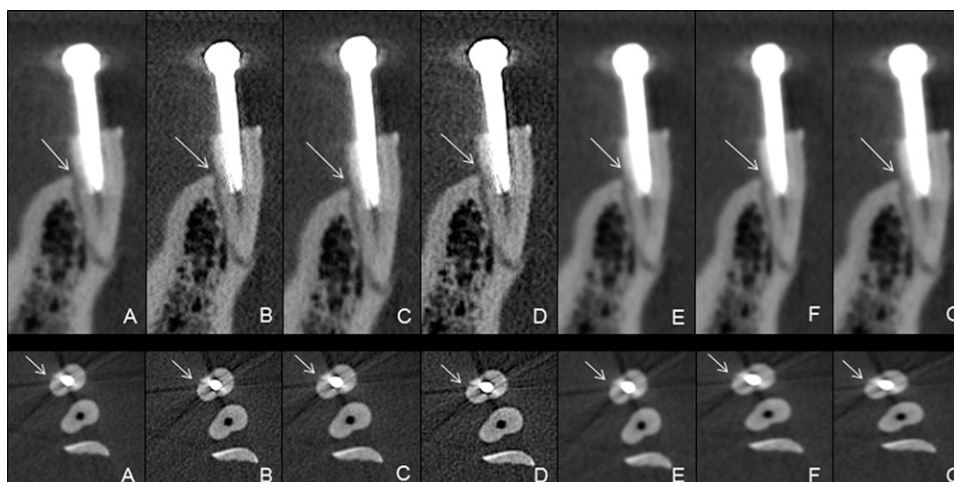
CBCT slices with (a) no filter, and (b) sharpen, (c) sharpen-mild, (d) sharpen 3 × 3, (e) S9, (f) smooth and (g) smooth 3 × 3 filters. Arrows indicate roots with fractures.
